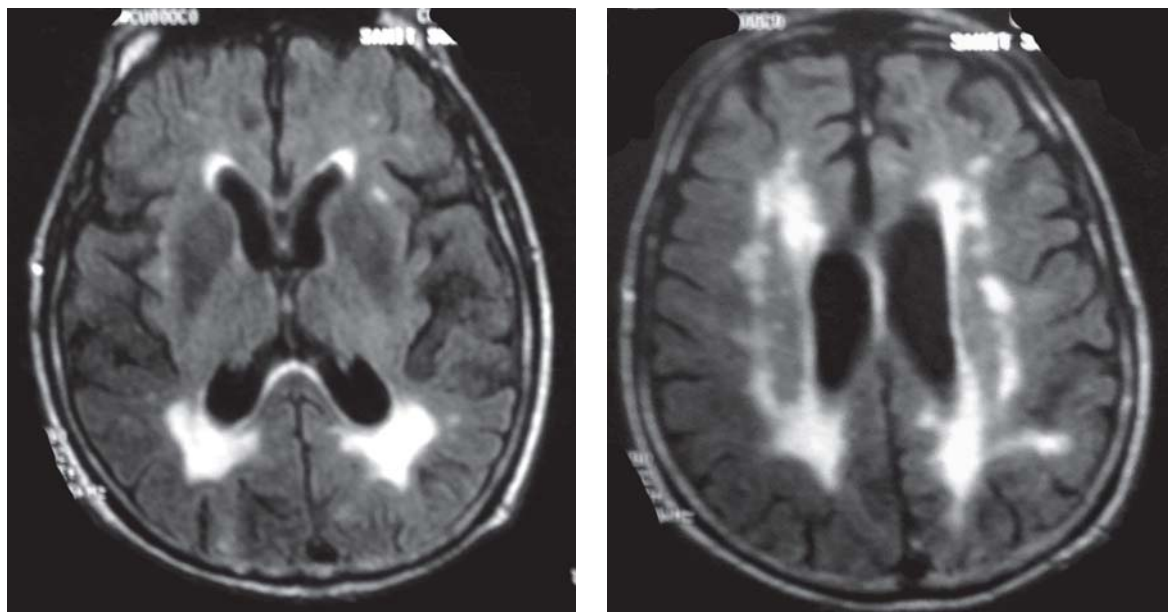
MRI (1A and 1B: FLAIR) images of a patient with extensive white matter disease
